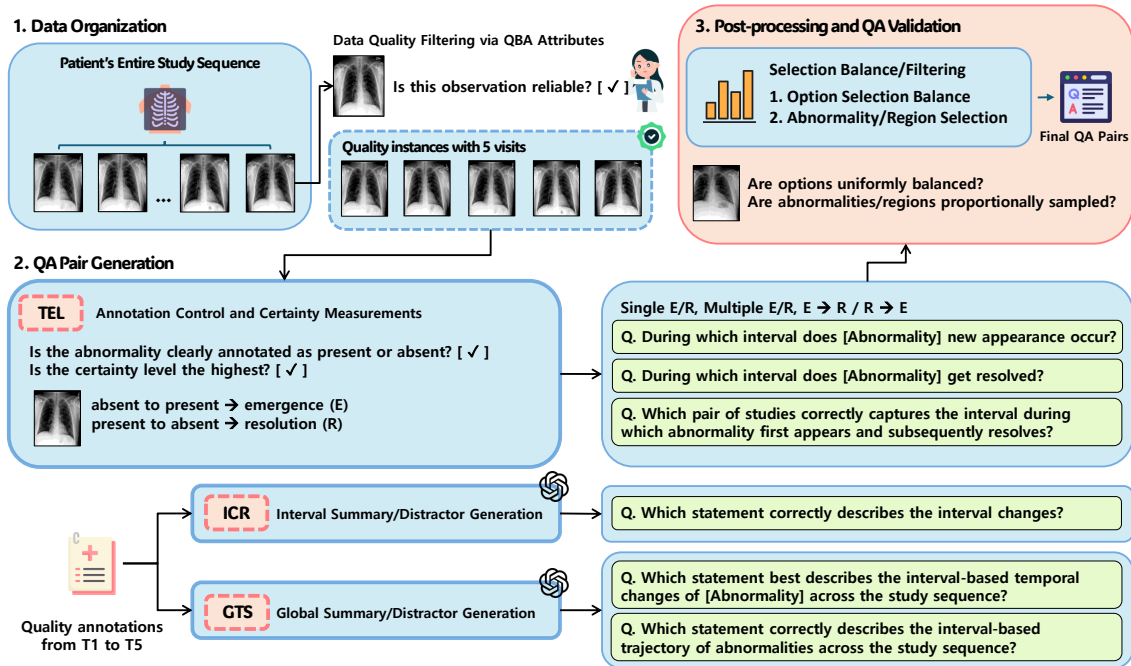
Overview of MI-CXR construction. We repurpose structured metadata from MIMIC-Ext-CXR-QBA and chest X-ray images from MIMIC-CXR-JPG to construct patient-level longitudinal timelines with at least five visits. After fixing the longitudinal cohort, multiple question types are instantiated from the same timelines to evaluate complementary longitudinal reasoning capabilities, including temporal event localization, interval-wise change reasoning, and global trajectory summarization.
